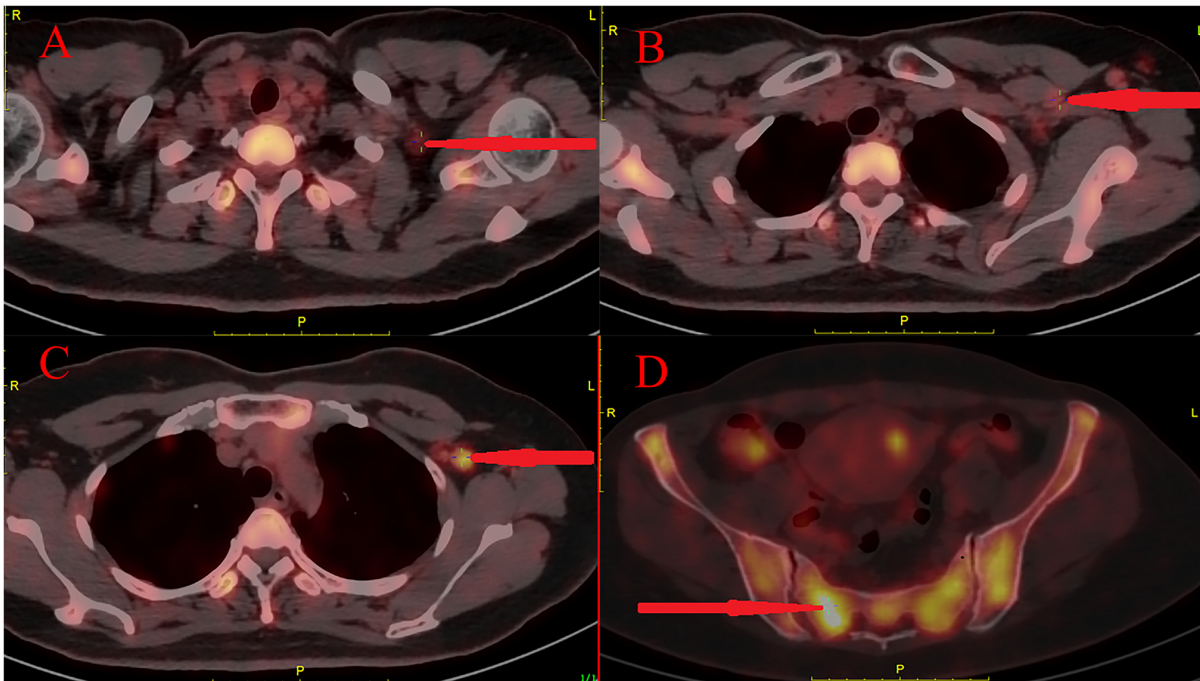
PET-CT images of each metastatic site. (A) Supraclavicular lymph node metastasis of breast cancer, (B) interpectoral lymph node metastasis, (C) axillary lymph node metastasis and (D) bone metastasis.
